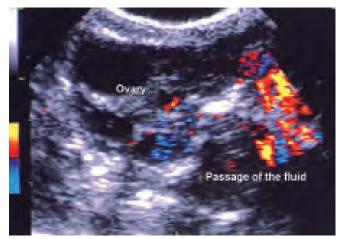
Transvaginal color Doppler Hy-Co-Sy demonstrates regular tubal patency. Note color flow signals passing through the right tube and simultaneous accumulation of the anechoic fluid in the cul-de-sac
